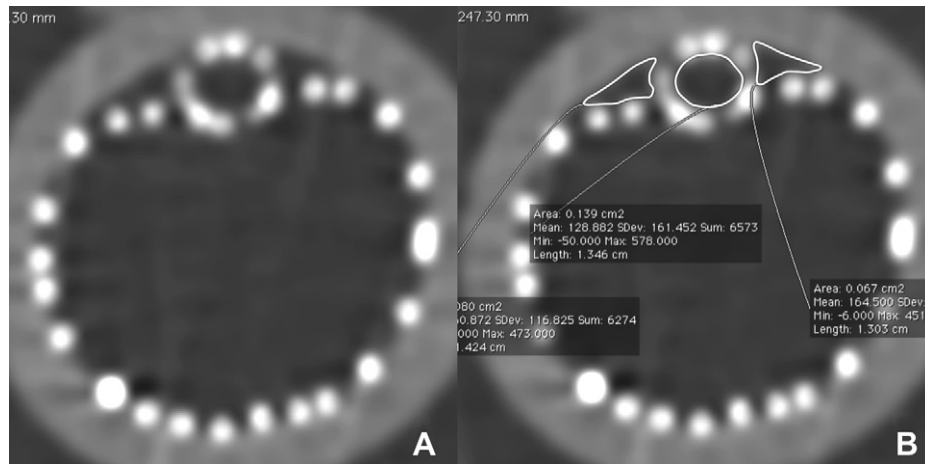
A) CT scan axial exam of an endograft–parallel stent model (Endurant–V12 combination), and B) measure of internal and external gutters area, and parallel-stent area.
